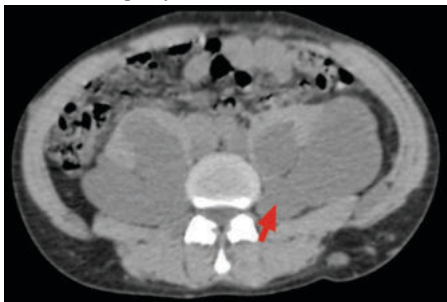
7 CT axial section abdomen shows bulky psoas muscle with multilobulated hypo dense lesion posterior to psoas muscle.
